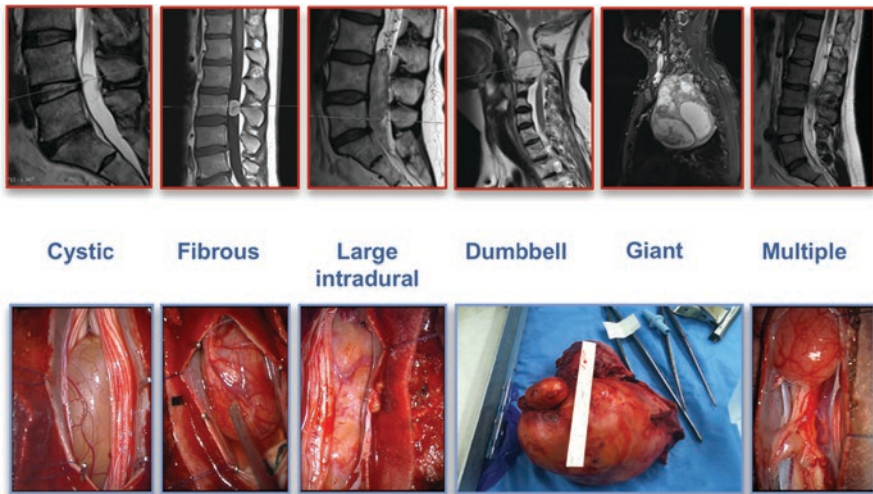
MRI and intraoperative characteristic of the nerve sheath tumors
